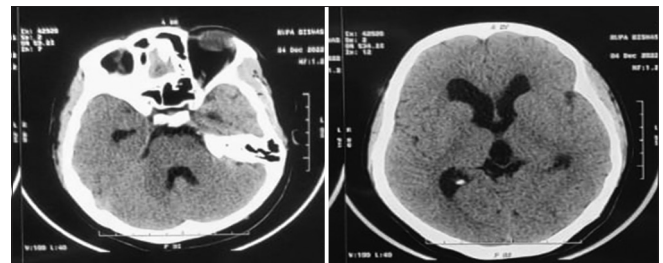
Non-contrast computed tomography brain, showing no parenchymal changes in brainstem, but horns of lateral ventricles are dilated
